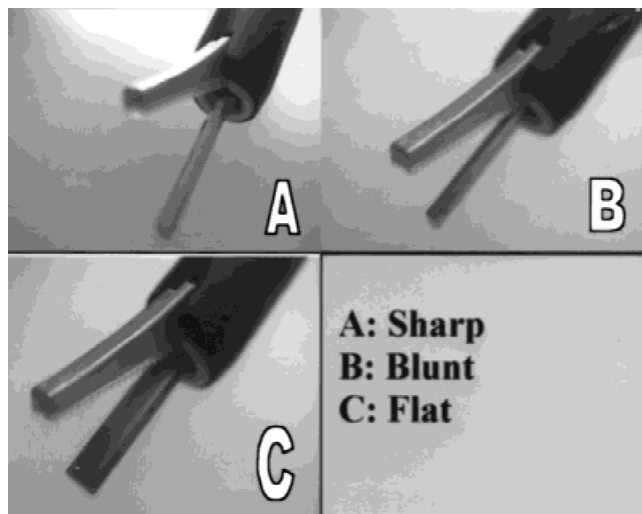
Positions of ultrasonic blade in three modes. A: Sharp mode. B: Blunt mode. C: Flat mode.
